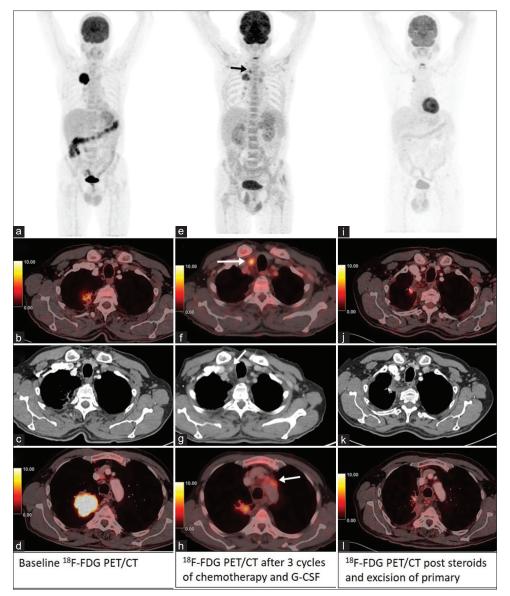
A 65-year-old male chronic smoker presented with complaints of cough, hemoptysis, loss of appetite, and weight for a year. Contrast-enhanced computed tomography (CECT) of the chest showed a soft-tissue mass in the right upper lobe of the lung, which was diagnosed with adenocarcinoma of the lung. Staging F-18 fludeoxyglucose positron emission tomography computed tomography (*F-FDG PET/CT) (maximum intensity projection image-(a), transaxial CECT and fused PET/CT images (b-d) showed an FDG avid heterogeneously enhancing soft-tissue mass in the right lung with pleural infiltration with mediastinal lymphadenopathy. He was started on neoadjuvant chemotherapy with pemetrexed and carboplatin. 6 mg of pegylated granulocyte colony-stimulating factor (G-CSF) was given subcutaneously on day two of every cycle, After completion of three cycles of chemotherpay he developed fever and underwent FDG PET/CT. MIP image (e) showed foci of tracer activity at new places in the thorax (arrow). Transaxial CECT and fused transaxial PET/CECT images revealed the appearance of FDG avid mural thickening along the right common carotid (SUVmax 7.3, ~6 mm thickness, images (f and g), origin of left subclavian artery and arch of aorta (images h, SUVmax 4.8), abdominal aorta at the origin of right renal artery (SUVmax 4.3), and left common iliac artery. A possible diagnosis of G-CSF-induced large vessel vasculitis was proposed as the cause of fever. His G-CSF was stopped and intravenous dexamethasone was given, which relieved his symptoms. Meanwhile, he underwent surgical resection of the lung lesion. A follow-up FDG PET/CT (MIP-I) and trans axial images (j-I) after 4 months showed resolution of the FDG avid thickening along the vessels, confirming the diagnosis of G-CSF-induced large vessel vasculitis
